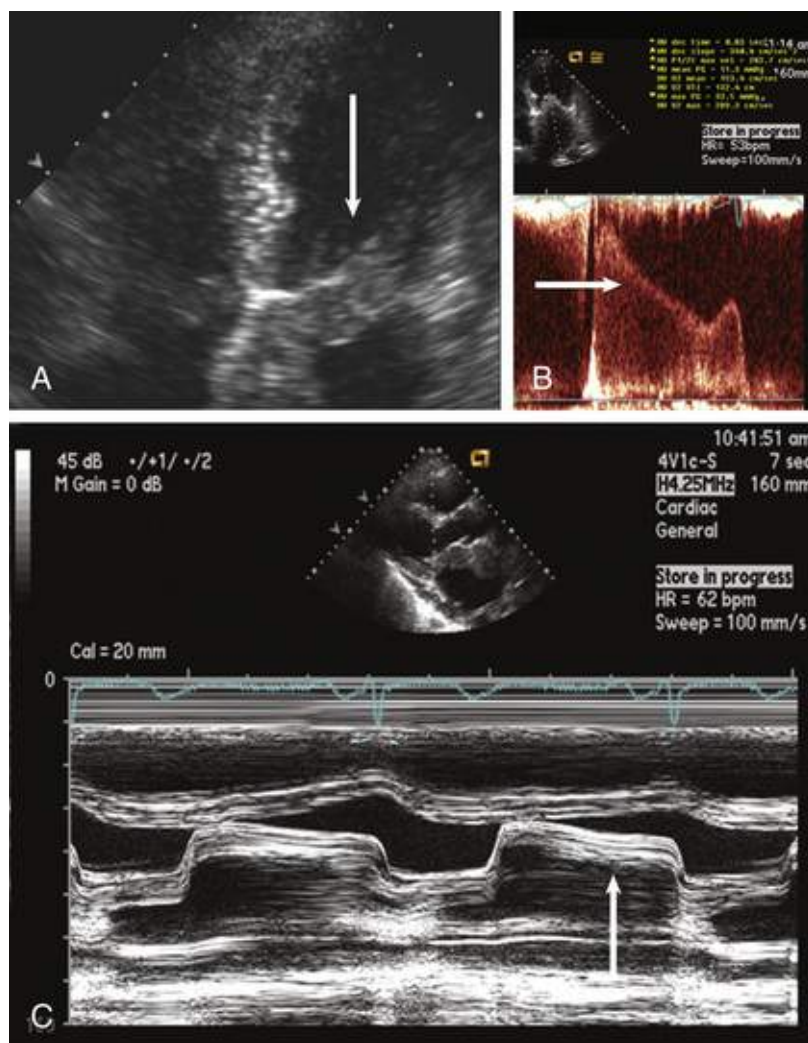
Echocardiographic Doppler images from a patient with sarcoma who presented with heart failure and mitral stenosis. A, Four-chamber image with mitral valve thickening (*arrow*). B, Increased velocity across the mitral valve showing stenosis (*arrow*). C, M mode showing a classic mitral stenosis pattern.
